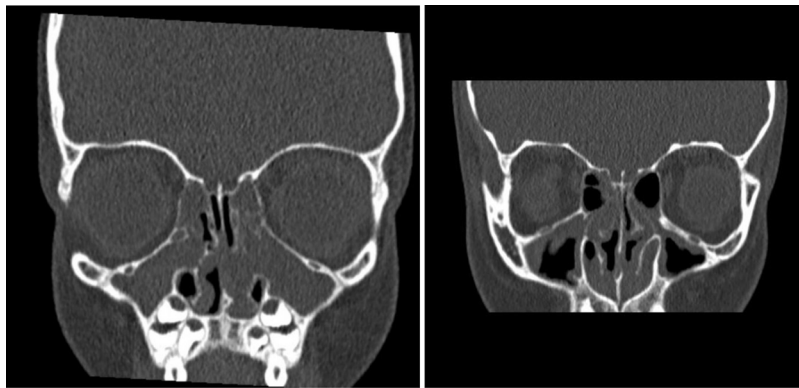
CT scans of patients with chronic sinusitis.
